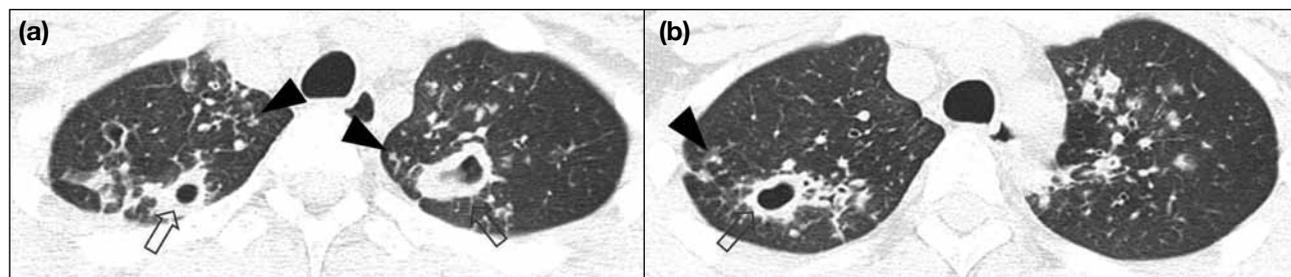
Primary multidrug-resistant tuberculosis in a 46-year-old man: transverse thin-section computed tomography scans show multiple cavities in both upper lobes (open arrows). Also note centrilobular nodules in both upper lobes (arrowheads).
